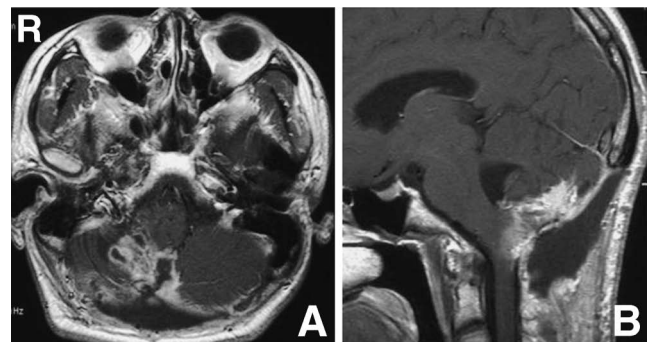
Axial (A) and sagittal (B) T₁-weighted magnetic resonance images with gadolinium after surgery and radiation therapy showing an enhanced residual tumor at the posterior fossa and attached to the medulla oblongata.
